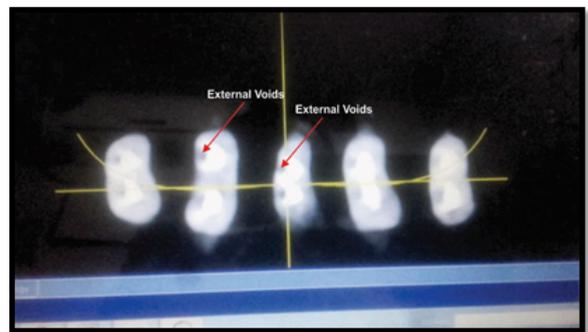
Screen shot of Axial view from above after CBCT
